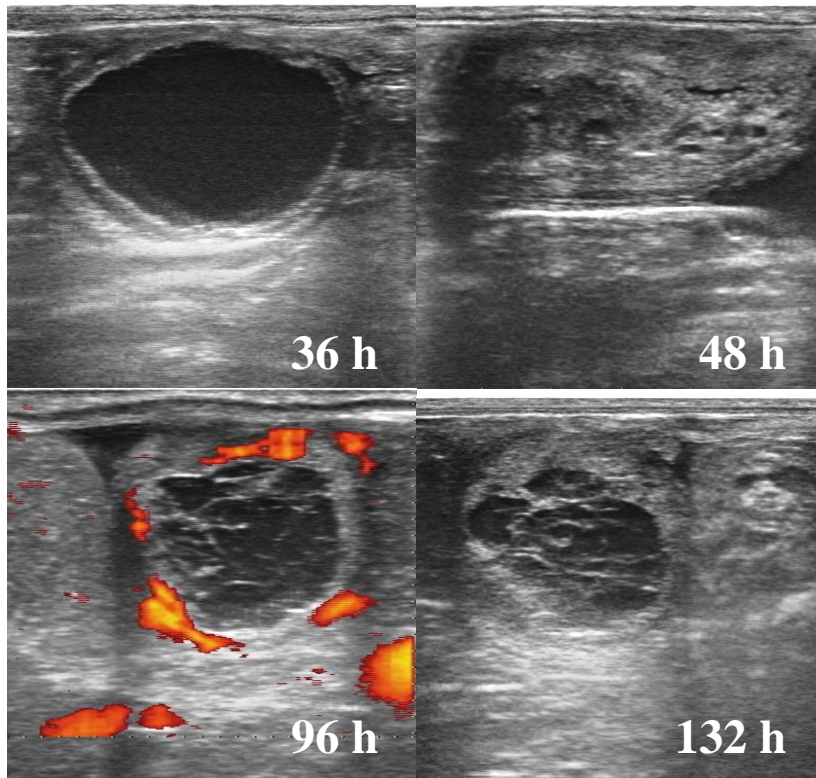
B-Mode and colour-Doppler (96 h) sonograms of a mare from the ovulatory-control group. The mare was only treated with 1500 IU of hCG i.v. (0 h). 36 h: preovulatory follicle with echoic-free follicular fluid. 48 h: ovary with ovulatory area, note the remaining anechoic follicular fluid (small pocket of black fluid). 96 h: the ovulatory area developed into a corpus haemorrhagicum with a central blood clot; note the high intensity colour-Doppler signals around the corpus haemorrhagicum periphery. 132 h: the central lacuna of the CH has contracted slightly.
